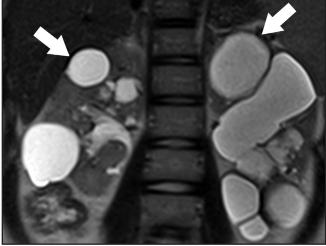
A 19-year-old woman with tuberous sclerosis. Coronal T2-weighted MR image shows multiple cysts (arrows) in bilateral kidneys without angiomyolipomas.
